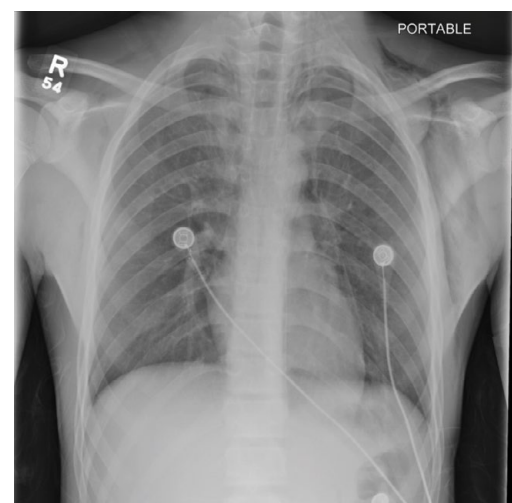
Pneumomediastinum on chest x-ray.
